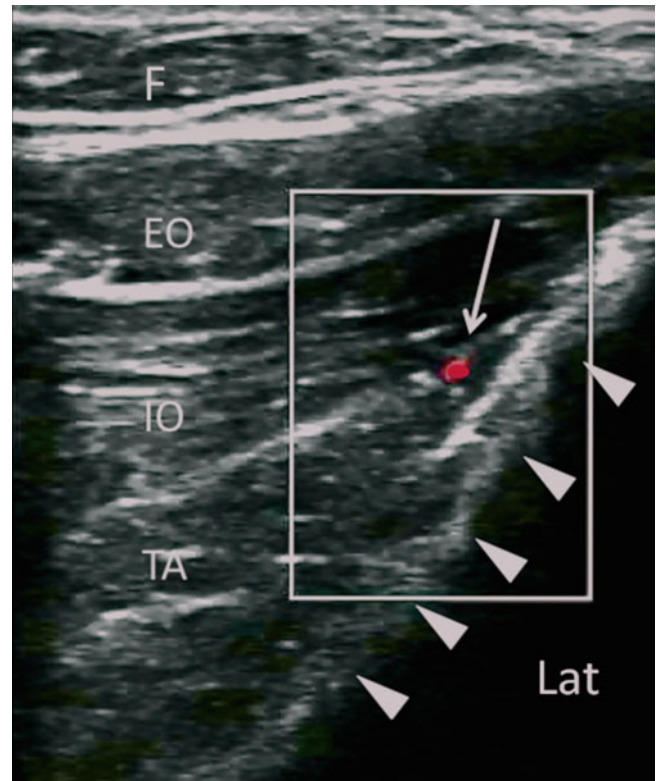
Similar view as in Fig. 54.3 with color Doppler. A branch of the deep circumflex iliac artery is shown in red color. Solid arrows outline the iliac crest. F subcutaneous fat, EO external oblique muscle, IO internal oblique muscle, TA transversus abdominis muscle, Lat lateral (Reproduced with permission from Philip Peng Educational Series)
